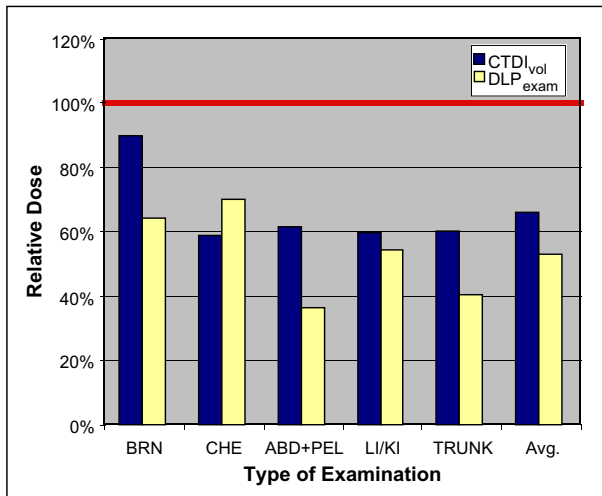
Comparison of the results of the 2003 UK CT survey (single- and dual-slice scanners) with those of the '99 German CT survey. Relative dose values are given for each type of examination in terms of volume CTDI per scan/rotation ($CTDI_{vol}$) and dose-length product per examination (DLP_{exam}). The red line at 100% represents the average of the '99 German CT survey for the pertaining type of examination and dose descriptor (for abbreviations see tab.1).
